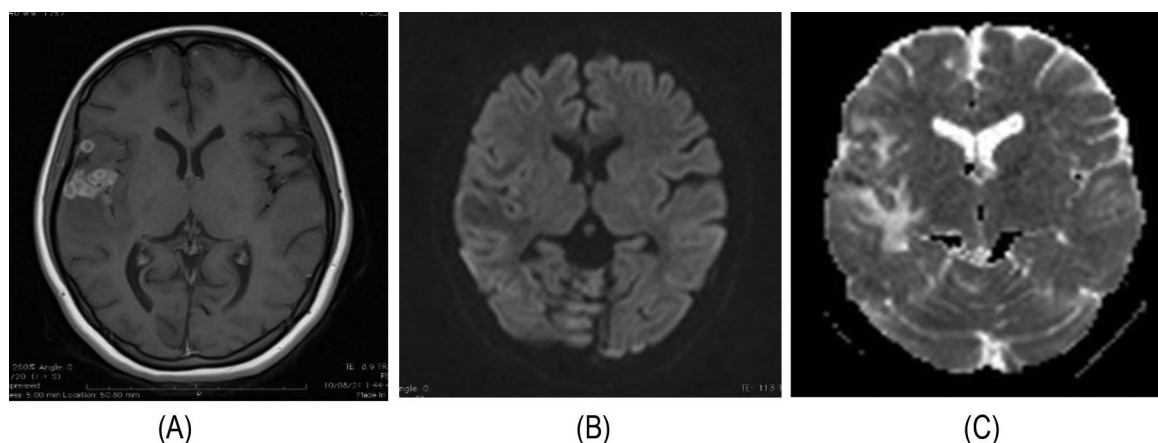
Axial T1W post contrast image of tuberculoma showing ring enhancement (A) and dark on DWI image (B), bright on ADC (C).
